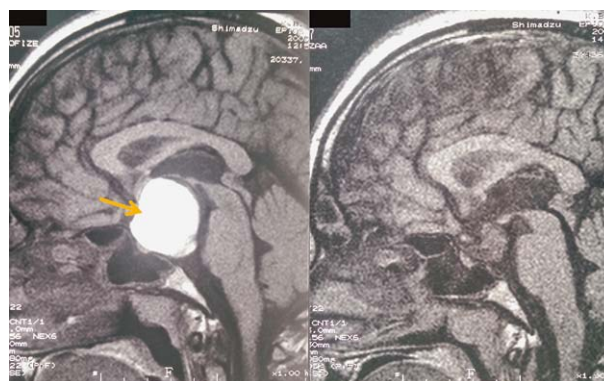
Brain magnetic resonance image before (left side) and after (right side) neurosurgical procedure. The arrow points to the cystic tumor (with a measured diameter of 3 cm).
